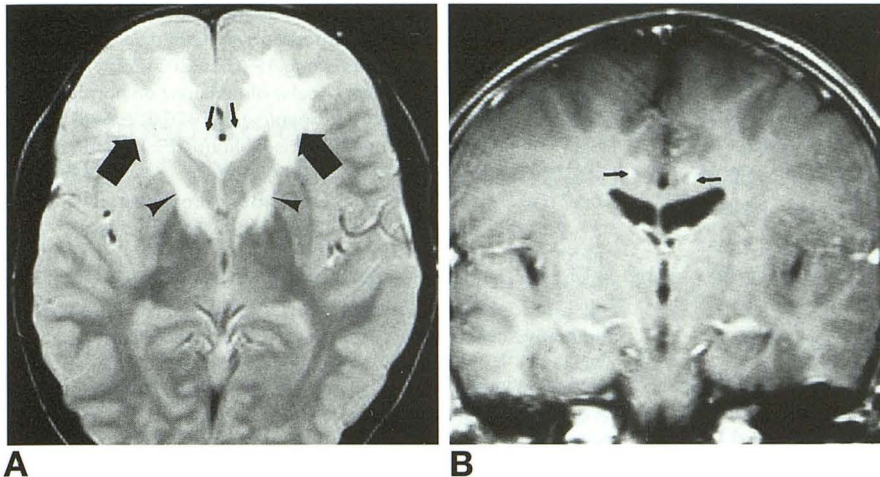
MR images in an 11-year-old boy with a frontal pattern of childhood-onset cerebral adrenoleukodystrophy.
